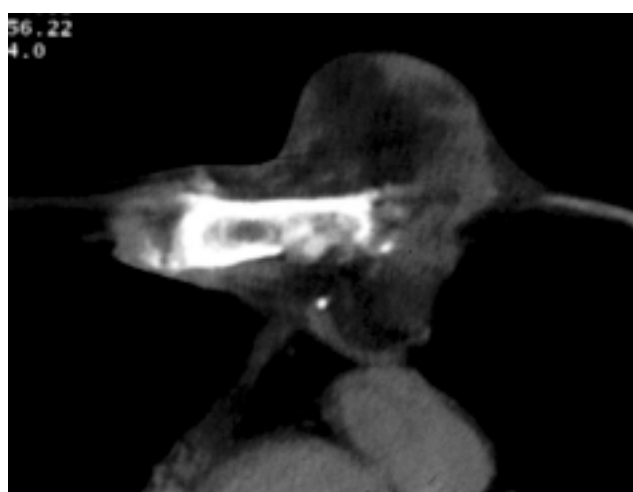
Chest computed tomography showing an inhomogeneous tumor with necrotic nonenhancing regions. Destruction of the sternum is also noted.
